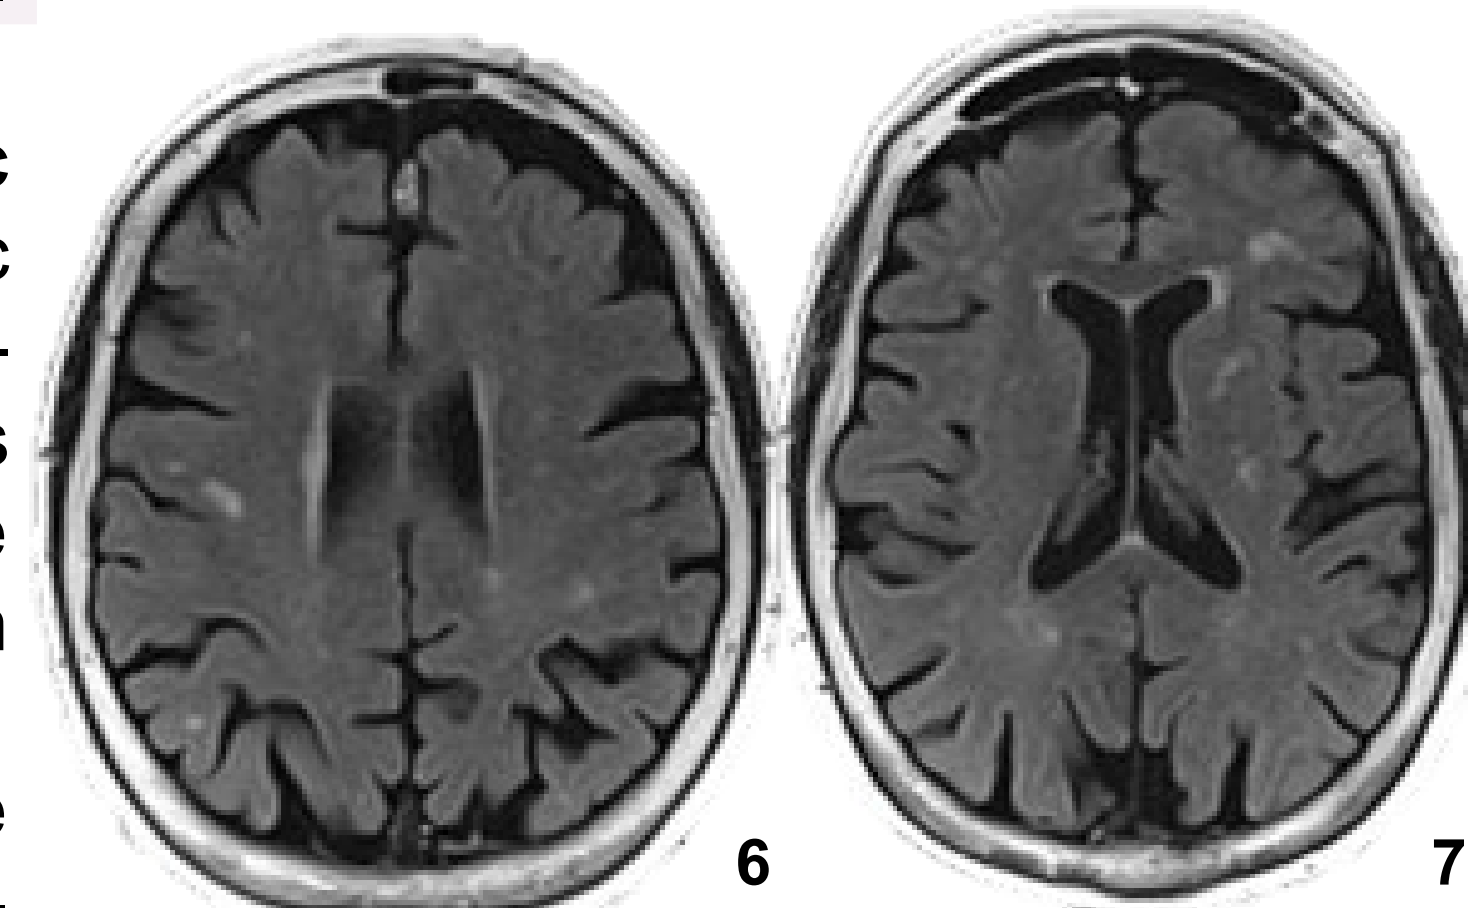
brain MRI showed bi-hemispheric white matter T2 hyperintensities and atrophy; spine MRI was normal. Note cerebellar atrophy
